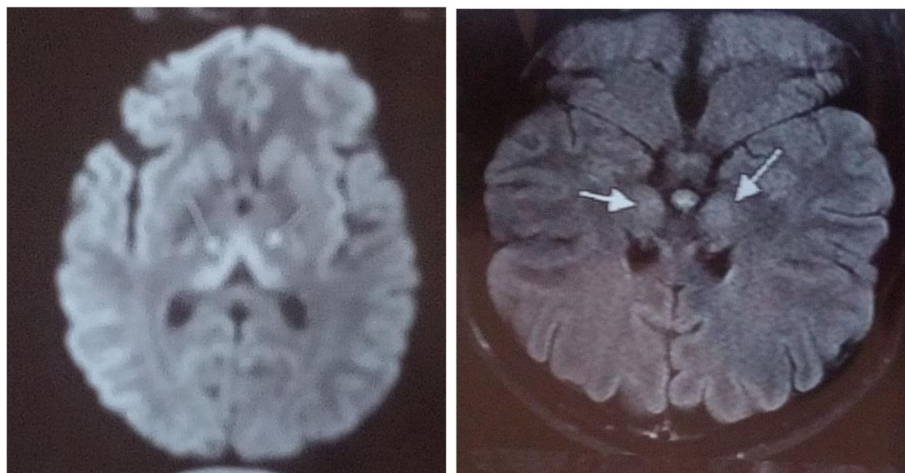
Image of the brain showing symmetrical hyperintensity in bilateral pulvinar nuclei of the thalamus on the MRI
